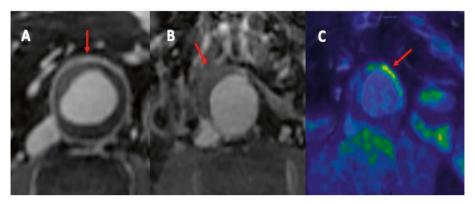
A) Gadolinium enhancement (arrow) in 42 mm abdominal aortic aneurysm (AAA) on T1 weighted magnetic resonance image (MRI). B) No presence of gadolinium enhancement (arrow) in a 36 mm AAA on T1 weighted MRI C) Focal uptake of 18F-Fluorodeoxyglucose (arrow) in 45 mm AAA
